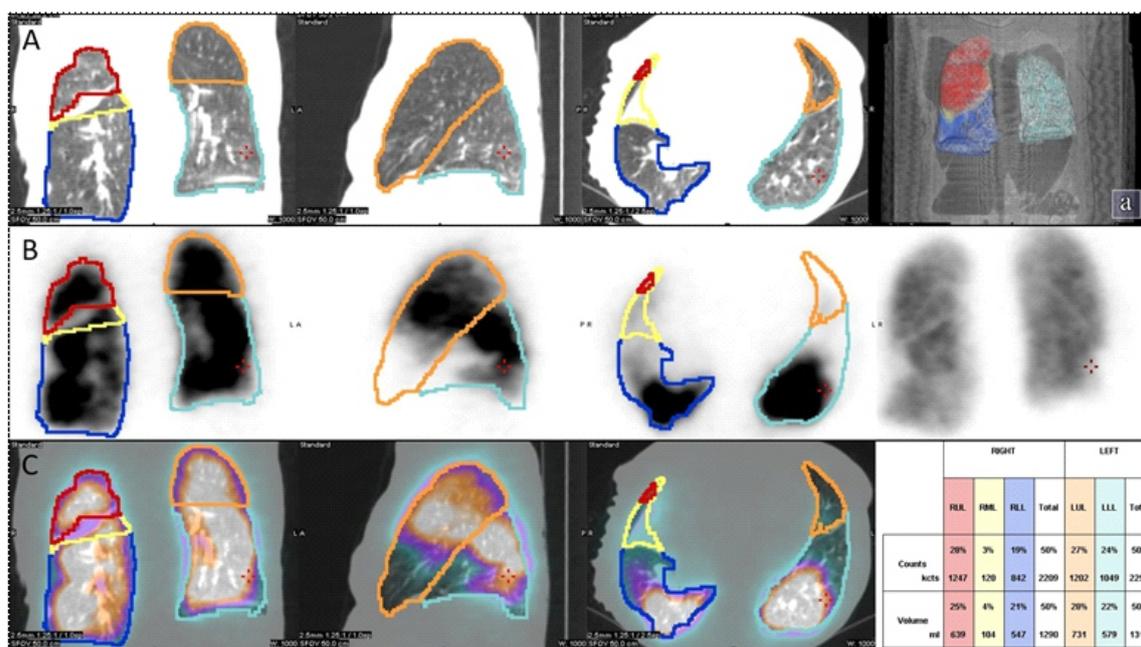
Coronal, sagittal, and transaxial slices of IdCT (line A), Q SPECT (line B), and Q SPECT/CT (line C) images in a patient with acute PE show multiple mismatched perfusion defects. ROIs for each lobe is semi automatically drawn in the sagittal CT images using the fissures as the anatomical reference. These ROI are also reflected in Q SPECT images and quantitate lobar perfusion, as seen right bottom (Q.Lung, Xeleris version 4.0, GE Healthcare).
